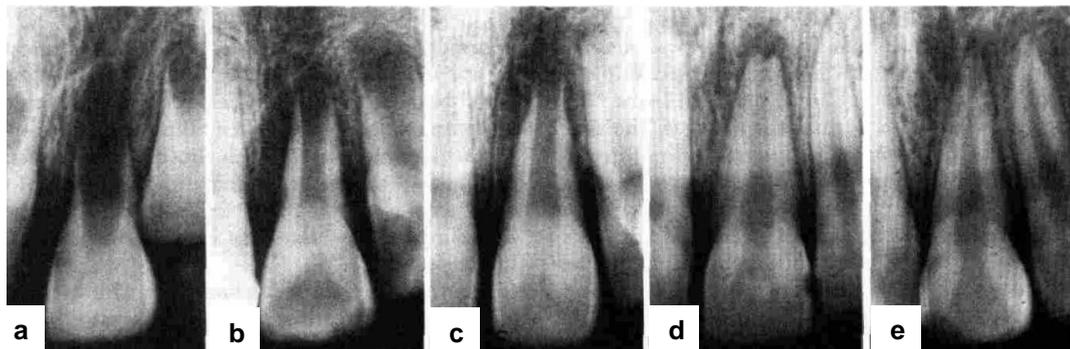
Radiographic classification on stages of root development (with permission to reproduce from John Wiley and Sons – see Appendix 7).
